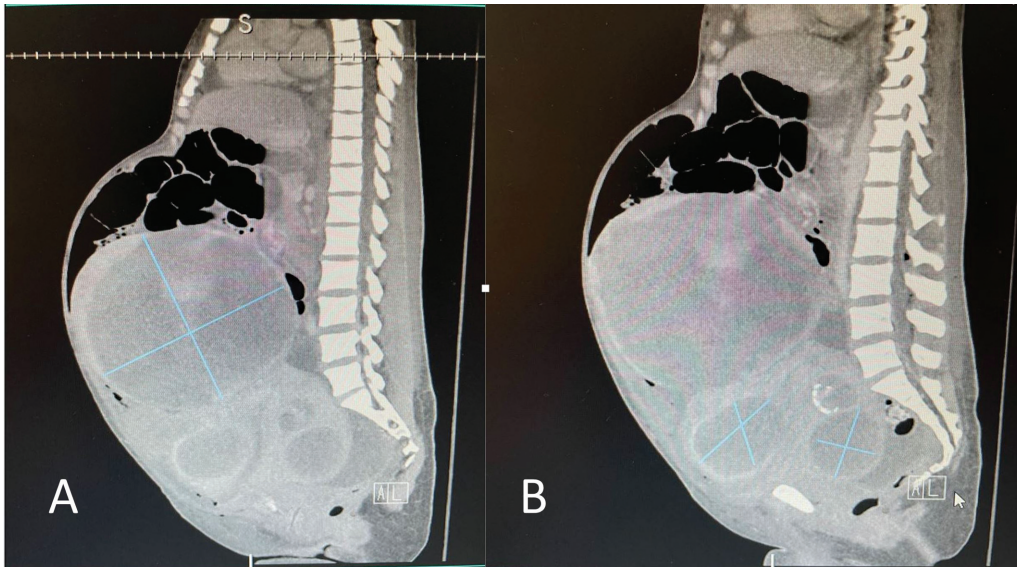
Computed tomography (sagittal) imaging of massive multifibroid uterus with dilated loops of bowel and large volume ascites. (A) Largest subserosal fibroid measuring 24 × 17 cm. (B) Multiple smaller fibroids measuring 6.7 × 5.8 cm and 4.2 × 4 cm.
